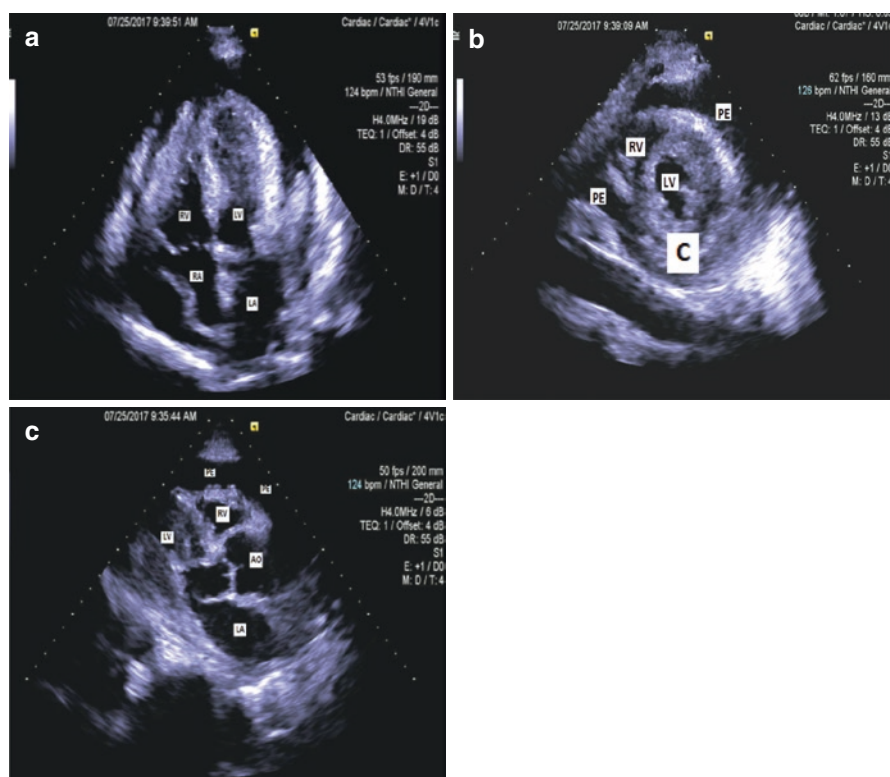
A 24-year-old woman with past medical history of mitral valve prolapse and recent symptoms of upper respiratory infection presents to the emergency department post-cardiac arrest. Transthoracic echocardiography revealed the following: (a) Apical four-chamber view: large pericardial effusion with right atrial and right ventricular collapse. (b) Parasternal short-axis view: Large pericardial effusion. (c) Parasternal long-axis view: large pericardial effusion. LV left ventricle, LA left atrium, RV right ventricle, RA right atrium, AO aorta, PE pericardial effusion
